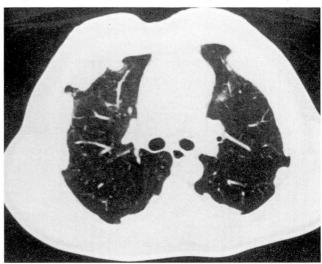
CT and high-resolution CT scans in a 69-yearold man with a history of prolonged heavy asbestos exposure. A CT scan (top) of the lower chest demonstrates multiple and bilateral minimally calcified large pleural plaques (arrows). Note the typical "squared" appearance of the pleural thickenings. The high-resolution CT scan through the mid-lung fields (immediately above) shows no evidence of interstitial fibrosis, which, if present, would suggest asbestosis.
